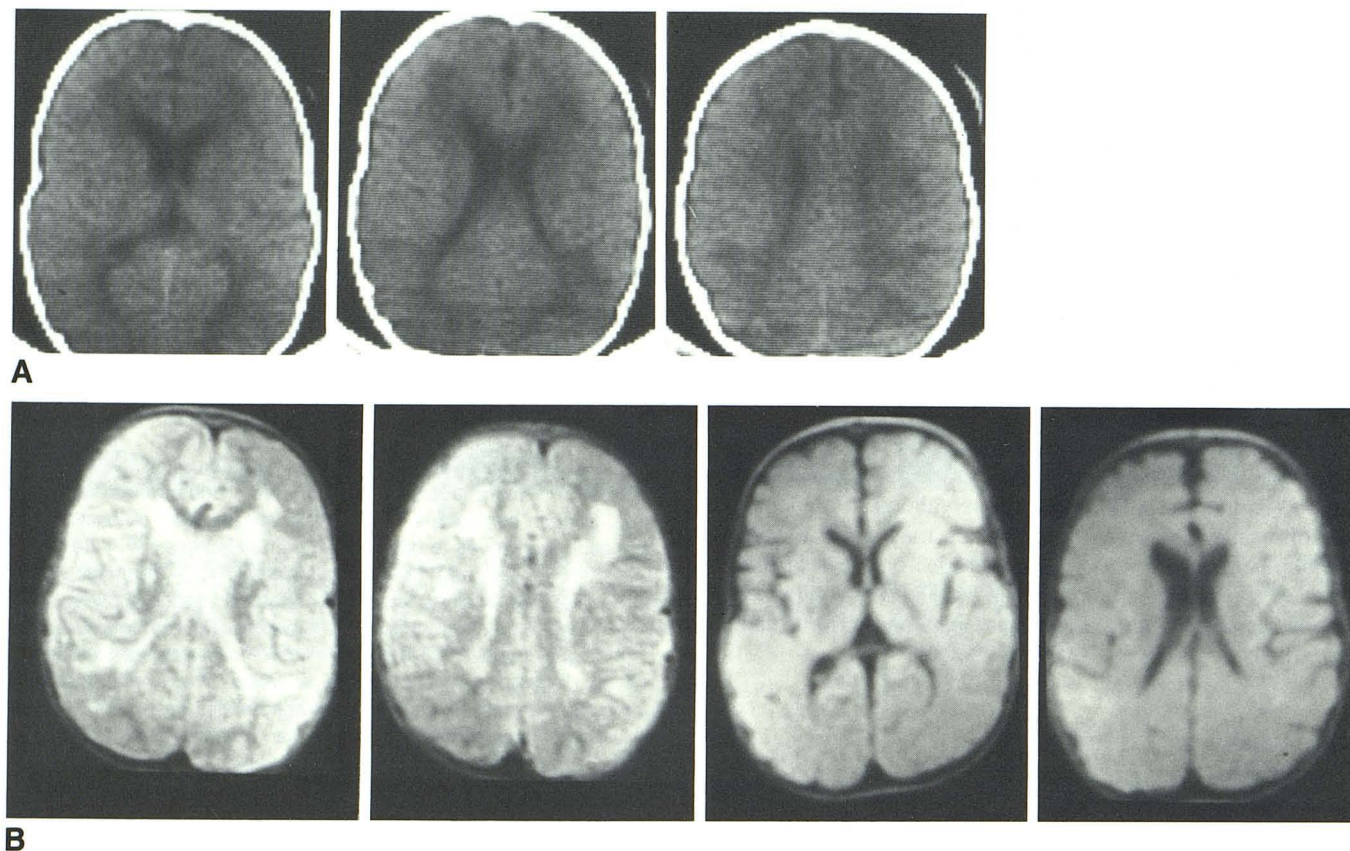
A, Contiguous unfused CT images show prominent periventricular white-matter lucency and increased convolutional markings. B, Top row: Contiguous 10-mm-thick T2-weighted MR images (TE = 80 msec, TR = 3000 msec). Patchy, irregular, round, abnormal areas of high signal intensity are present in periventricular white matter. Bottom row: Contiguous 10-mm-thick slightly T1-weighted MR images (TE = 40 msec, TR = 800 msec) fail to show abnormal signal from white matter. (See discussion in text.)
